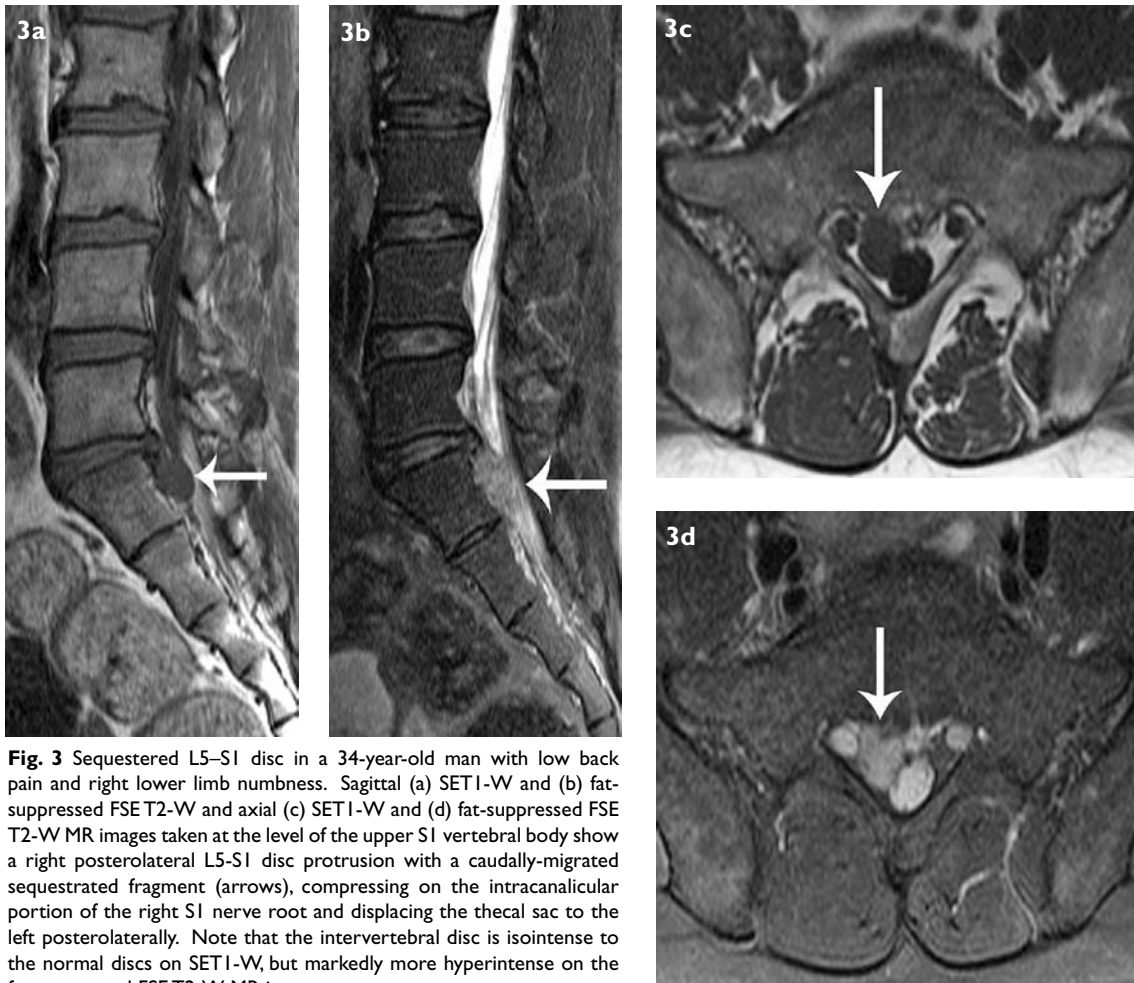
Sequestered L5-S1 disc in a 34-year-old man with low back pain and right lower limb numbness. Sagittal (a) SET1-WV and (b) fat-suppressed FSE T2-WV and axial (c) SET1-WV and (d) fat-suppressed FSE T2-WV MR images taken at the level of the upper S1 vertebral body show a right posterolateral L5-S1 disc protrusion with a caudally-migrated sequestered fragment (arrows), compressing on the intracanalicular portion of the right S1 nerve root and displacing the thecal sac to the left posterolaterally. Note that the intervertebral disc is isointense to the normal discs on SET1-WV, but markedly more hyperintense on the fat-suppressed FSE T2-WV MR images.
